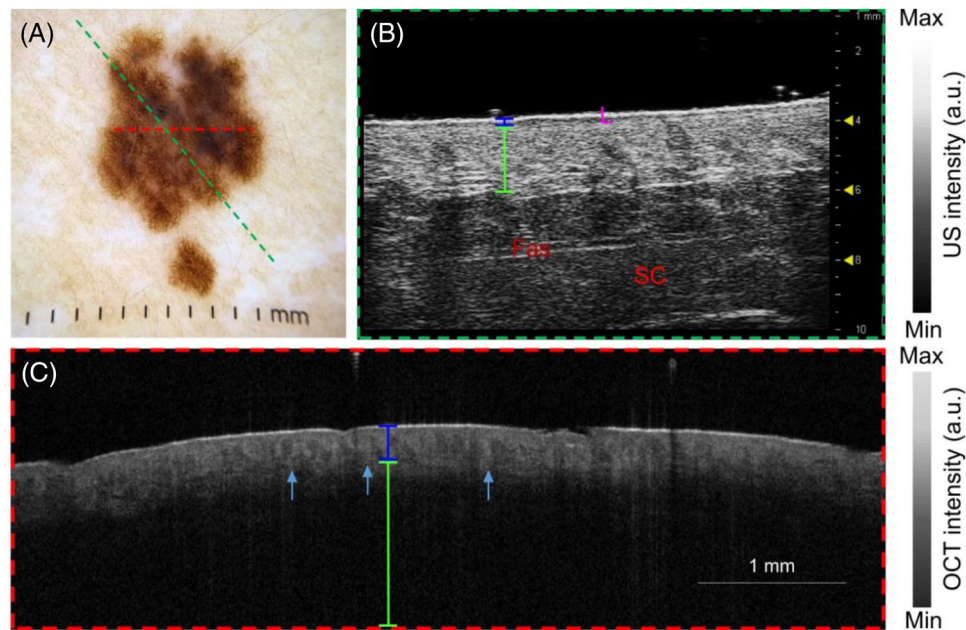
Compound nevus (CN) of phacomatosis pigmentokeratotic (PPK) on the chest. (A) Dermoscopy image of CN-chest with central black-brown globules are present with peripheral reticular network (RN). Red dashed line—optical coherence tomography (OCT) probe field (6 mm). Green dashed line—high-frequency ultrasound (HFUS) probe field 16 mm. (B) HFUS image of the CN-chest. L—lesion with hypoechoic “straw hat sign.” Blue line—epidermal entry echo. Green line—dermis. SC—subcutis. Fas—fascia. (C) OCT image of the CN-chest. The epidermis blends homogenously into the dermis due to proliferation of melanocytic nests. Blue line—epidermis. Green line—dermis. Red dashed ovals—blood vessels. Blue dashed line—outlines the junctional portion of the CN, demonstrated by RN on dermoscopy. White dashed line—outlines the compound portion of the CN.
